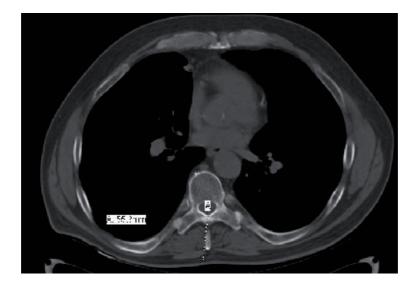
Measurement of depth of epidural space on CT scan
